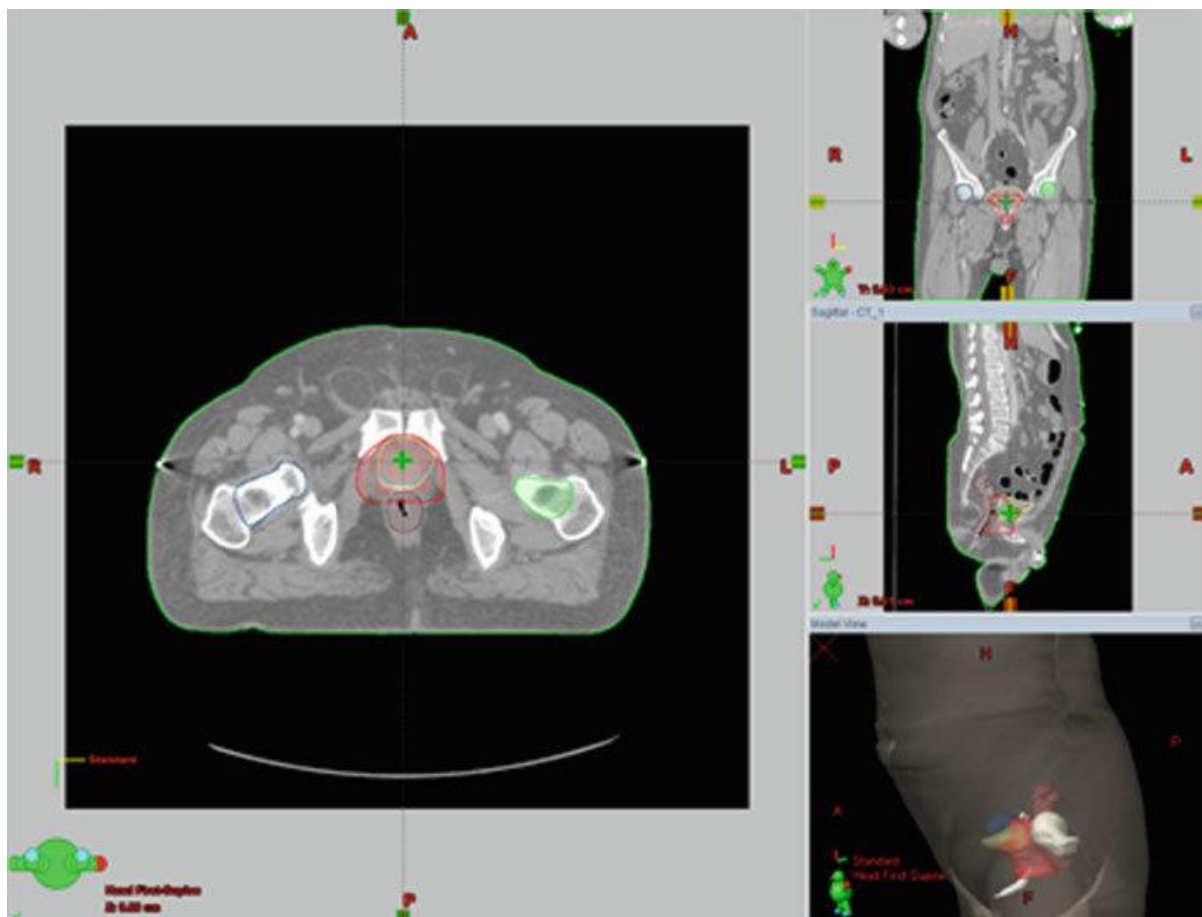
Three-dimensional view of the patient anatomy, reconstructed from CT data in Eclipse™
